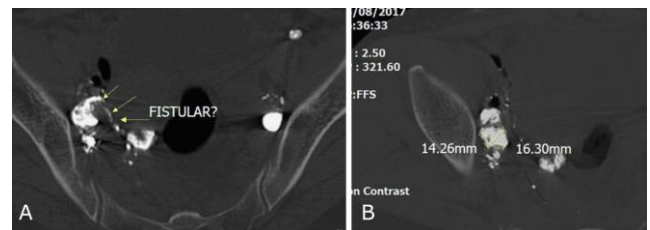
Abdominal CT scanner one day after the first intervention; Embolic agents filled in the aneurysm and the fistula (arrow) (A); In another hand, there might be some compartments in the aneurysm which had not been filled by embolic agent, resulting in existing leakage (B)
